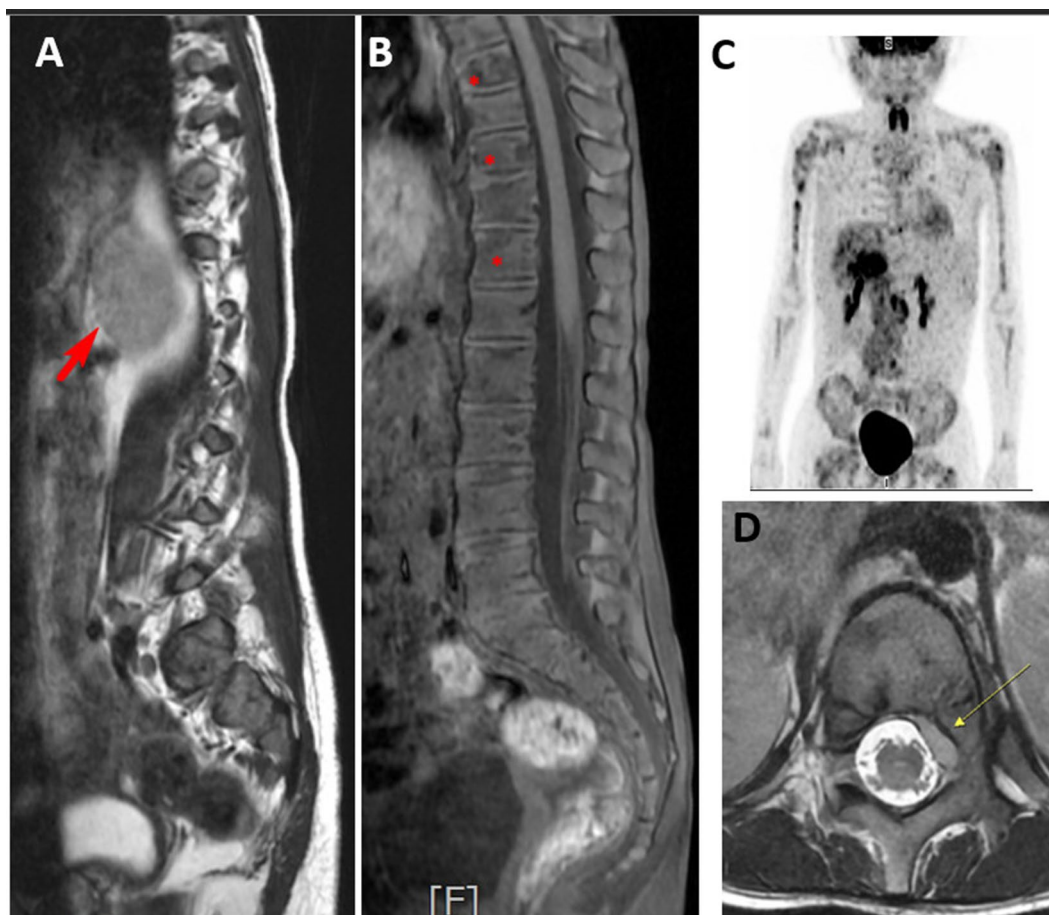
A 4-year-old girl with bone metastasis from right adrenal neuroblastoma. (A) Sagittal MRI showing a large, heterogeneous mass in the right adrenal gland, indicated by the red arrow. (B) Sagittal MRI showing multiple vertebral lesions with low intensities, marked by red asterisks (T7, T9 and T11). These lesions show altered signal intensity compared to normal vertebral marrow, indicating metastatic involvement. (C) F-18 FDG Whole Body PET Scan: The areas of increased uptake correspond to sites of active tumor growth, including the primary adrenal mass, spine, and possibly other distant organs such as the liver or lymph nodes. The overall pattern of distribution suggests extensive dissemination of neuroblastoma cells. (D) Axial MRI at the T12 level showing a metastatic spread of neuroblastoma mass in the left epidural space (yellow arrow), leading to neurological symptoms such as pain, weakness and sensory deficits. MRI, Magnetic Resonance Imaging; F-18 FDG, Fluorodeoxyglucose (F-18); PET, Positron Emission Tomography
